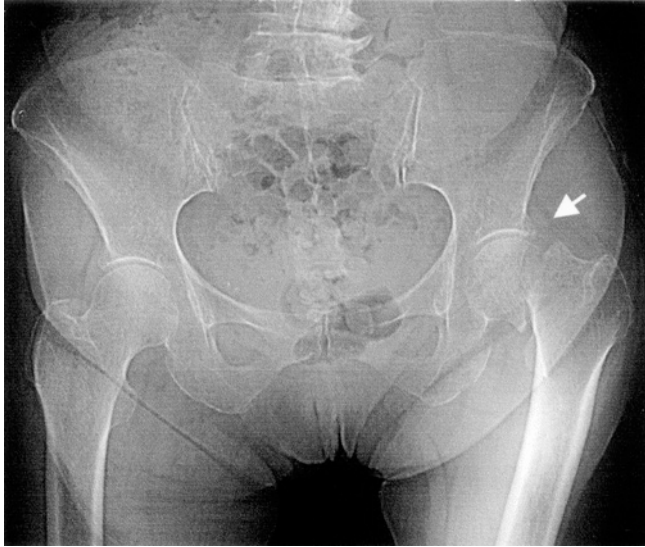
A plain radiograph of the hip showed fracture of the left femur (arrow).
